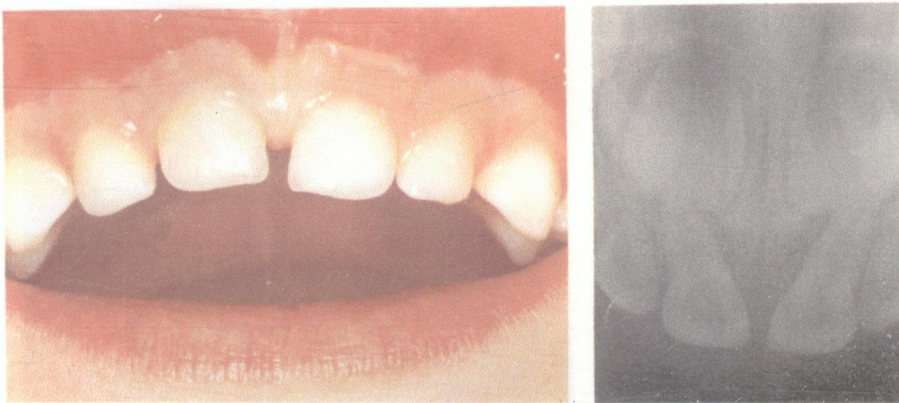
Follow-up 1 year after injury. The tooth is in normal position. Crown colour is normal and the radiograph shows no sign of pathology.
